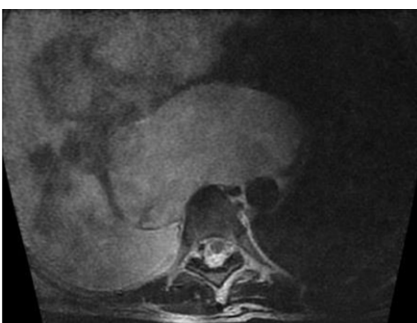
Axial T2 weighted MRI sequence
